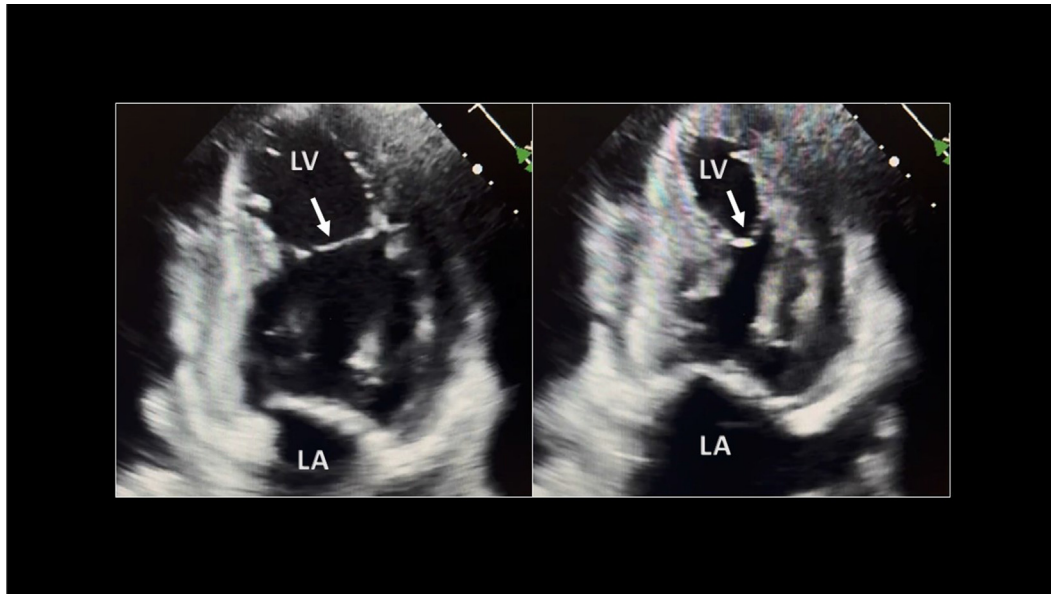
Two-dimensional transthoracic echocardiography, apical 2-chamber view, diastolic (*left*) and systolic (*right*) frame, demonstrates normal LV size and function with a visible, echo-bright linear false chord (*arrow*) connecting the anterior to the inferior midwall segment. The chord is taut in diastole and lax (bowed) in systole. LA, Left atrium.
